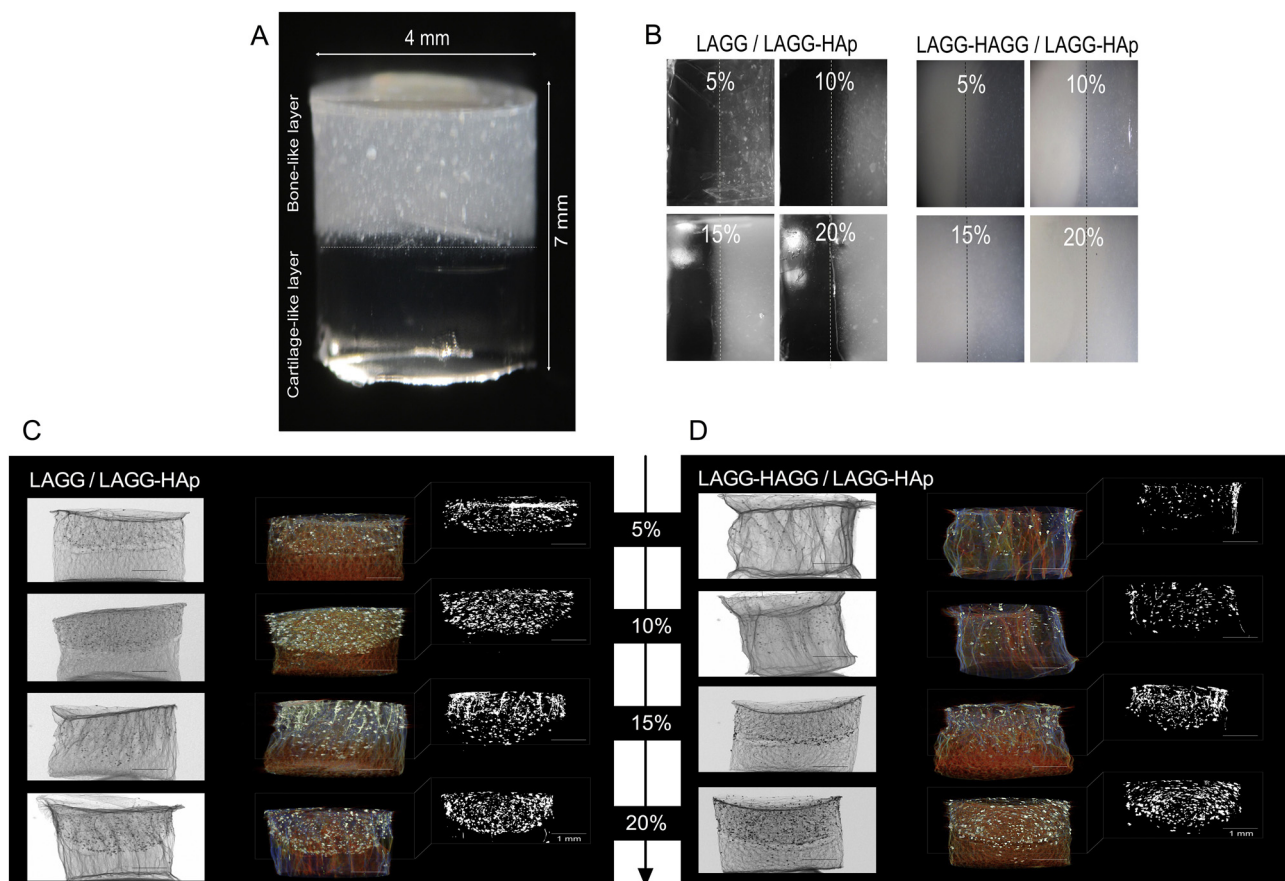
BHC microstructure and HAp distribution. (A) Macroscopic views of the BHC with 4 mm diameter \times 7 mm height and close up images at the BHC interface for each different BHC fabricated. μ -CT analysis of the BHC for (C) LAGG/LAGG-HAp and (D) LAGG-HAGG/LAGG-HAp. Scale bar represents 1 mm.
